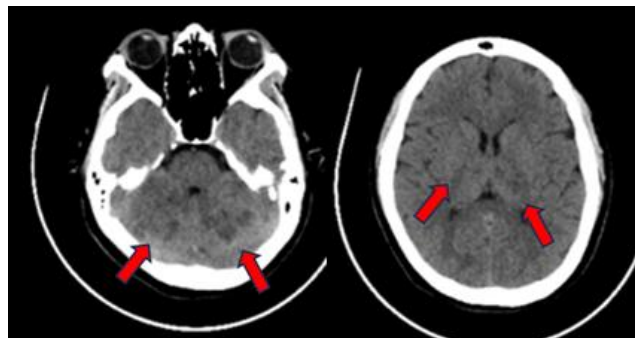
Non-contrast head CT scan showed relatively well-defined hypodense lesions in the bilateral thalamus and cerebellum (red arrow)
